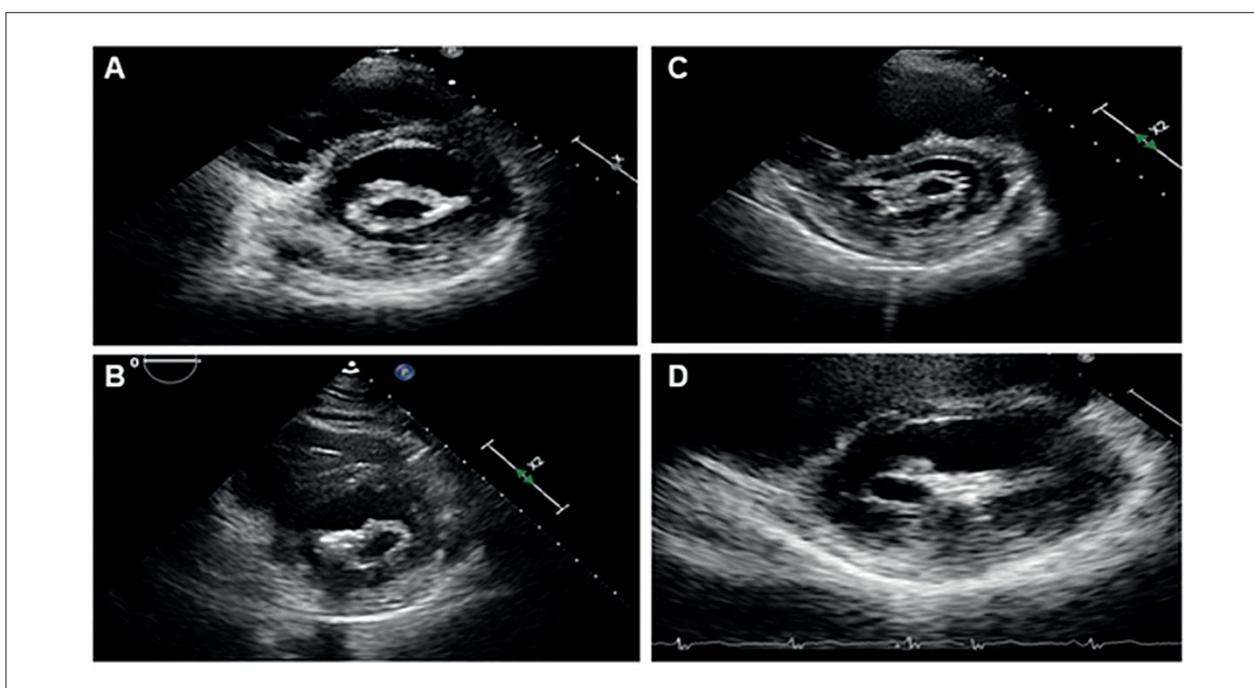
Patterns of commissural involvement (parasternal short axis view). A: symmetrical commissural involvement. B/C: commissural asymmetry with predominance of thickening and calcification of the posteromedial commissure. D: large valvular deformity and commissural asymmetry with predominance of thickening and calcification of the anterolateral commissure.
